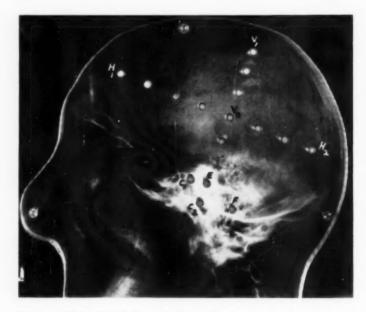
Positions of ionization chambers in Perspex plate for dosage measurements in brain, shown on radiograph of hemicranium (cf. Table II).
